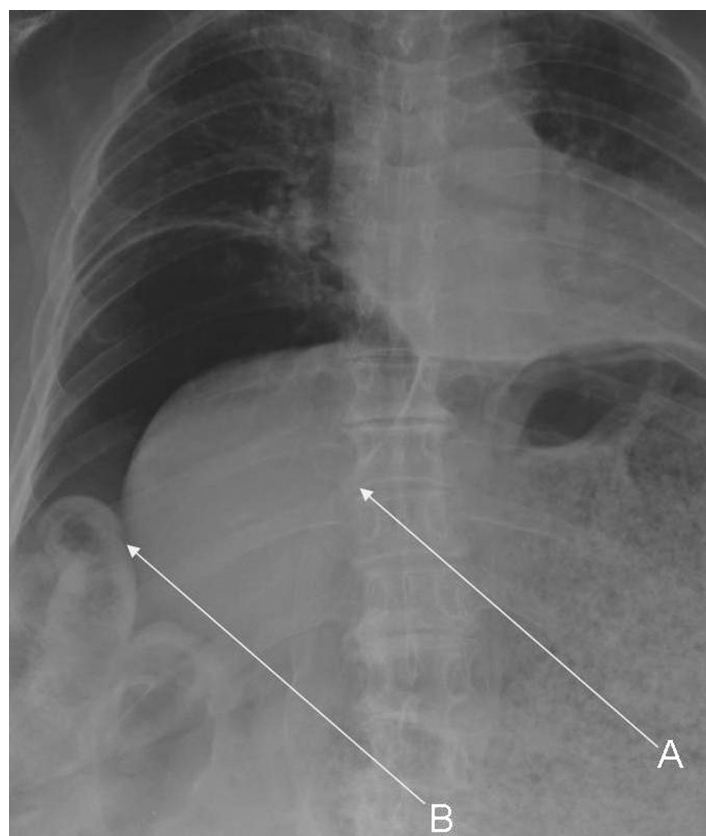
Abdominal radiograph showing football (A) and Rigler's signs (B).
